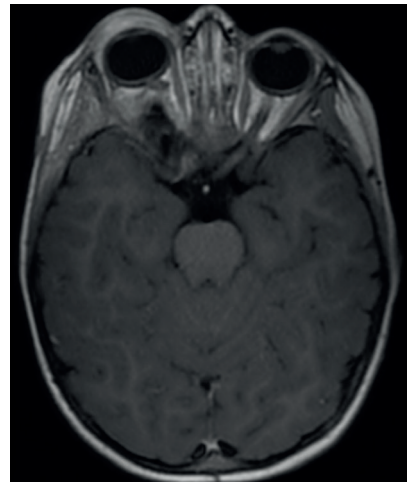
First Follow up after 3month of T1-weighted MRI of the brain (axial) showed gross total resection of the tumor and no residue of tumor
